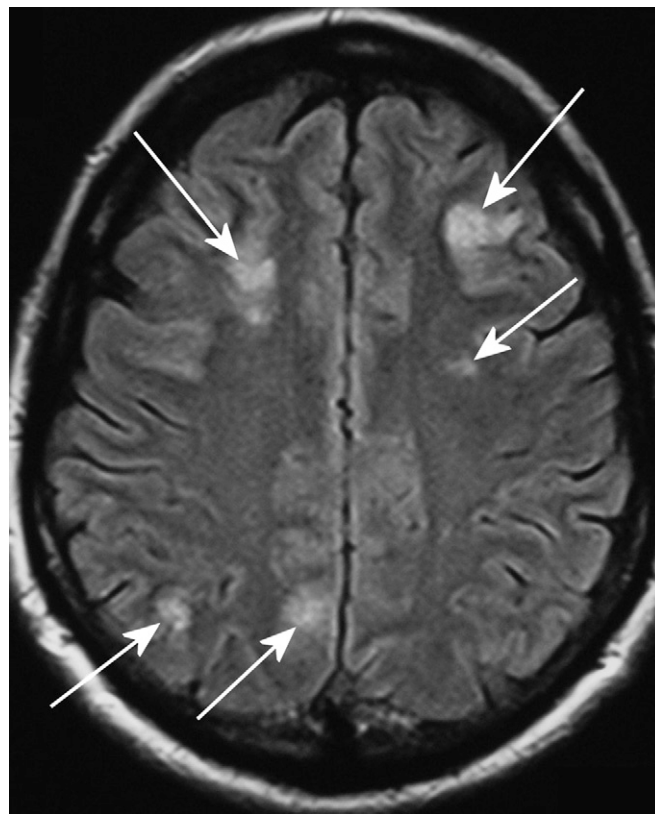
Initial FLAIR MRI images through frontal and parietal lobes showing multiple cortical lesions involving the bifrontal areas, likely due to microvascular ischemia (solid arrows).
